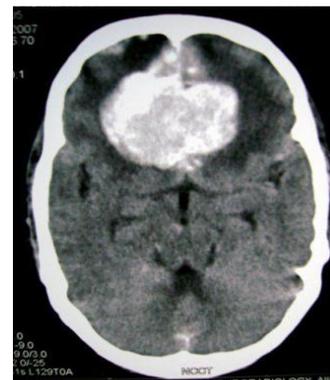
CT brain scan with tumor
